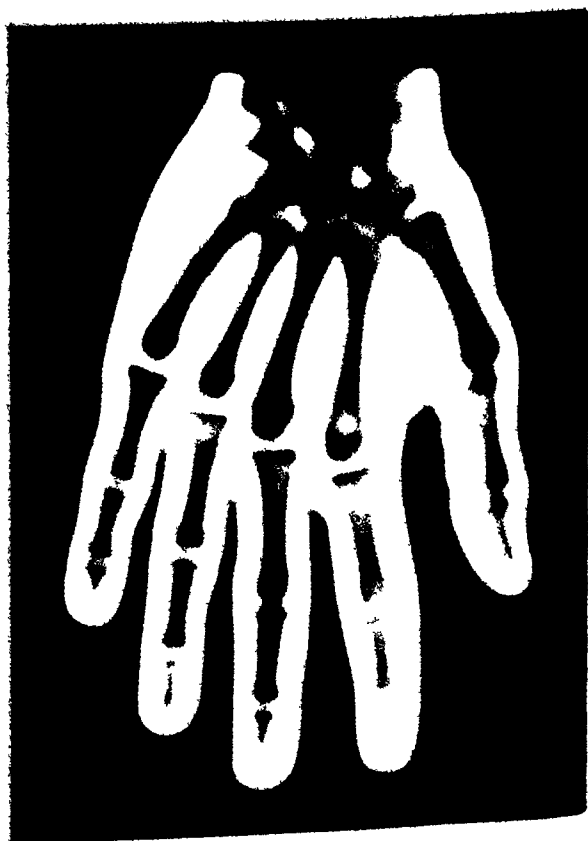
HAND ORDINARY RADIOGRAPH
